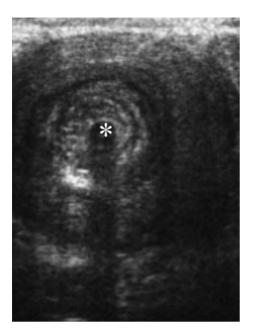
A 7-year-old girl with HSAN type II. A jejunostomy was placed because of feeding problems. Despite her condition she complained of cramping abdominal pain. The ultrasound image shows an ileo-ileal intussusception around the jejunostomy tube (*asterisk*). The abdominal pain was relieved after changing the jejunostomy catheter
